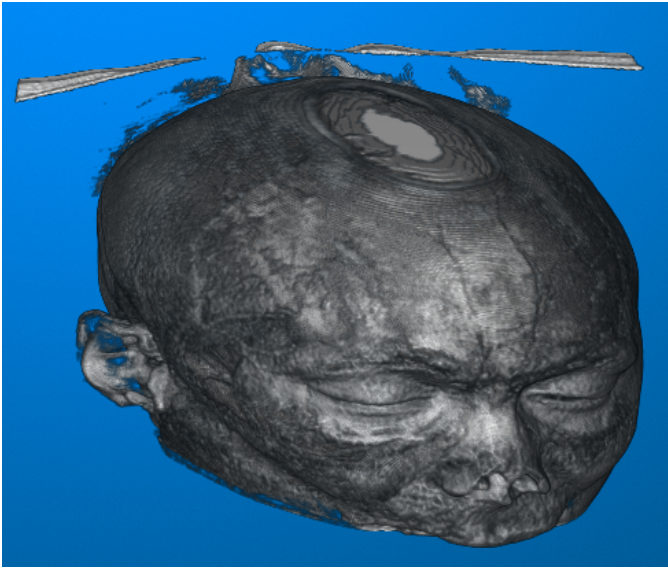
The 211 CT head slices in 3D. Similar to Figure 1, the slices on CT-MRI DB are found under `./Images-Patient-240163-01/<first_folder>/4/`.
